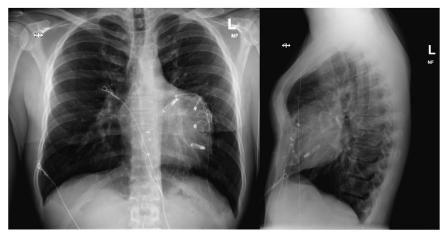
PA and lateral chest radiograph.
